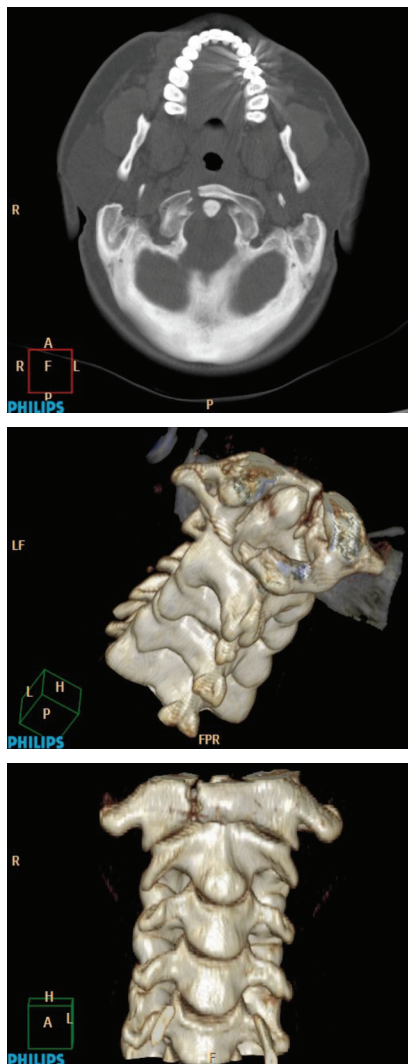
CT scan (upper image: axial slice, center and lower images: three-dimensional reconstruction) showing fractures of the right anterior arch and left posterior arch of the C1 vertebra.
